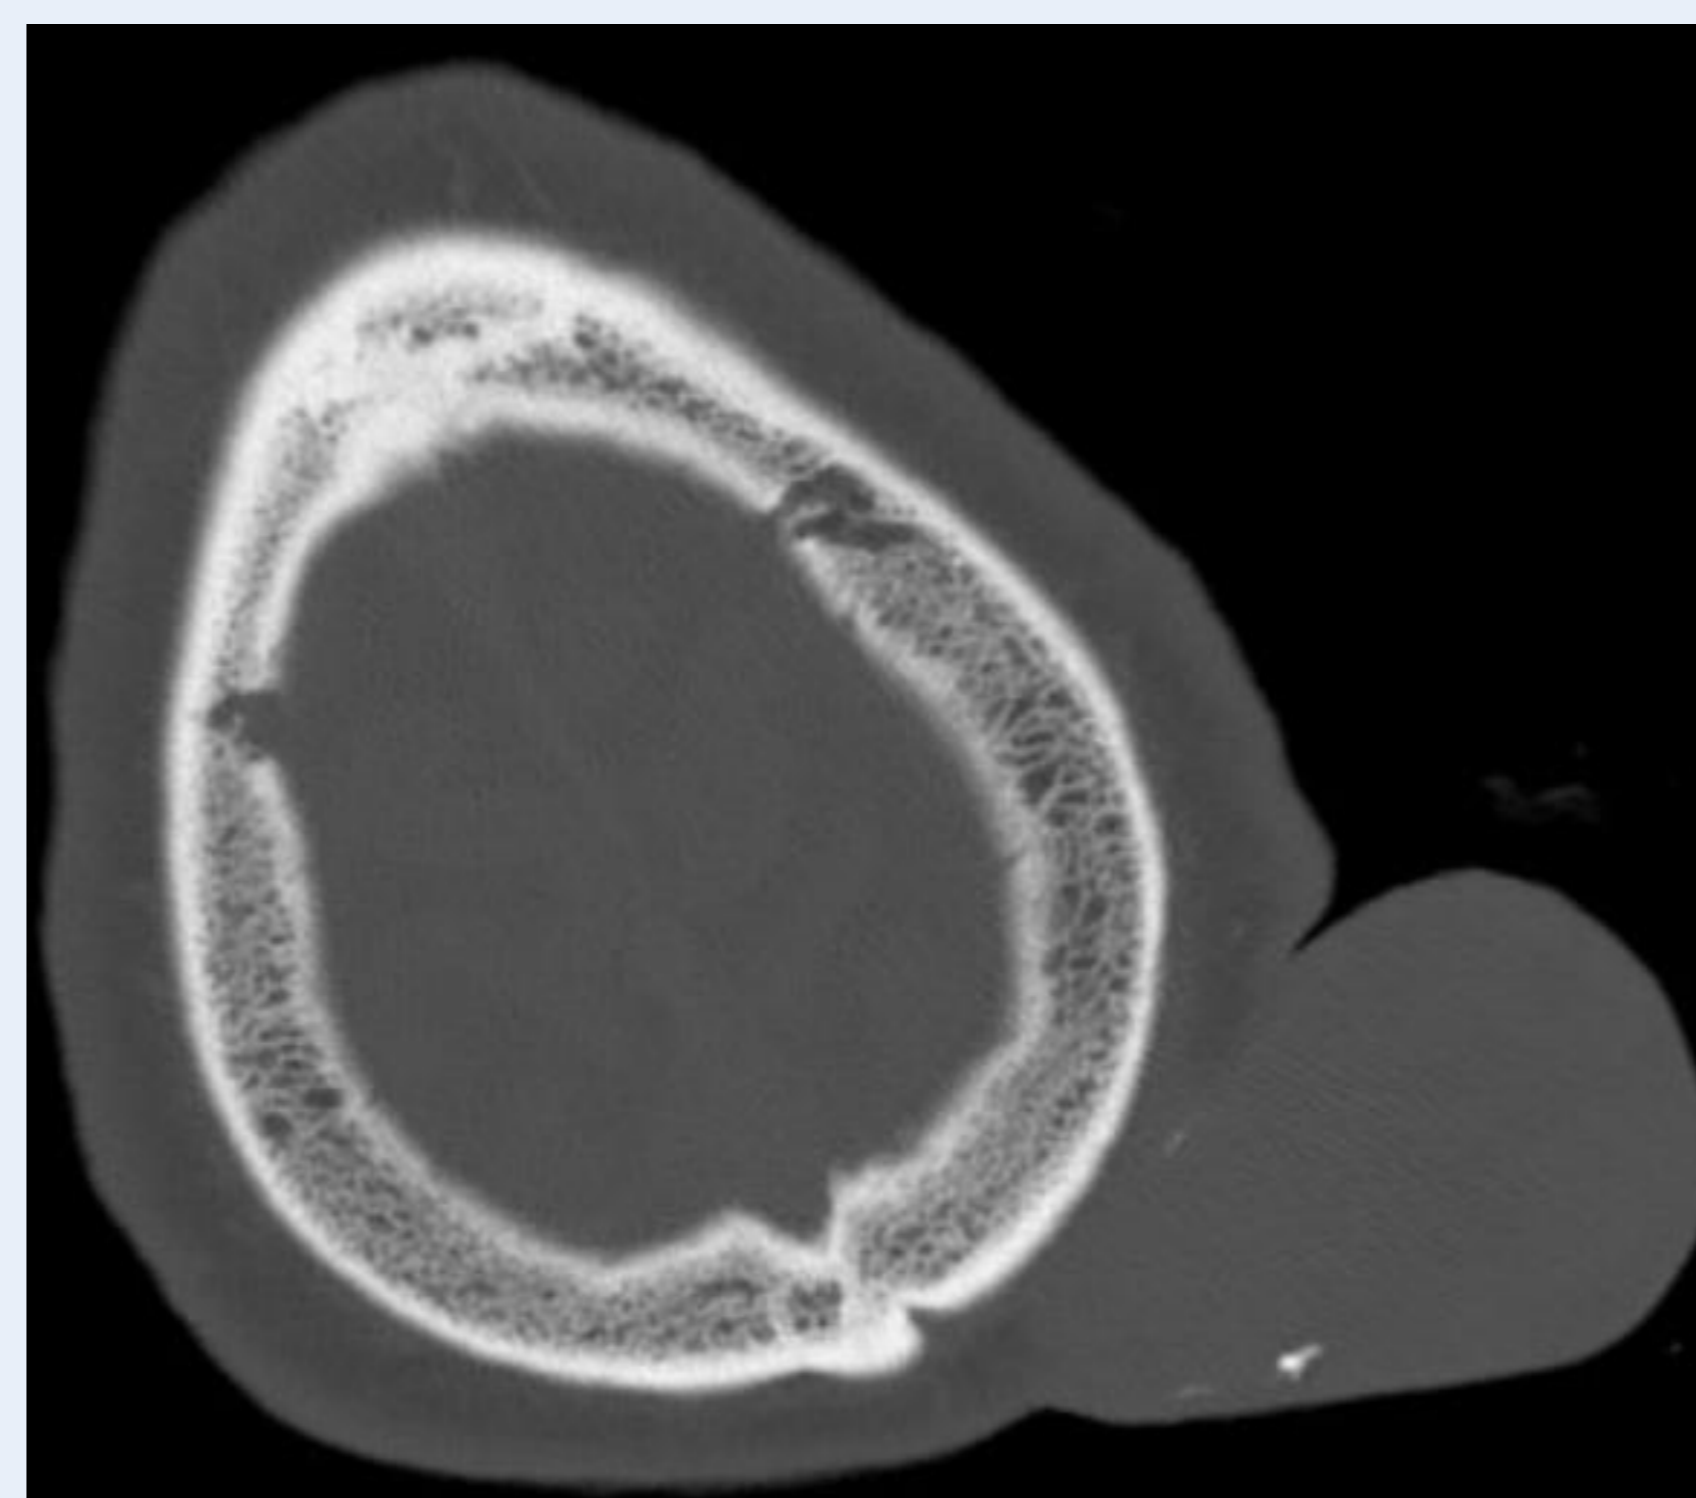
Preoperative CT showing no erosion or invasion of the adjacent bone
